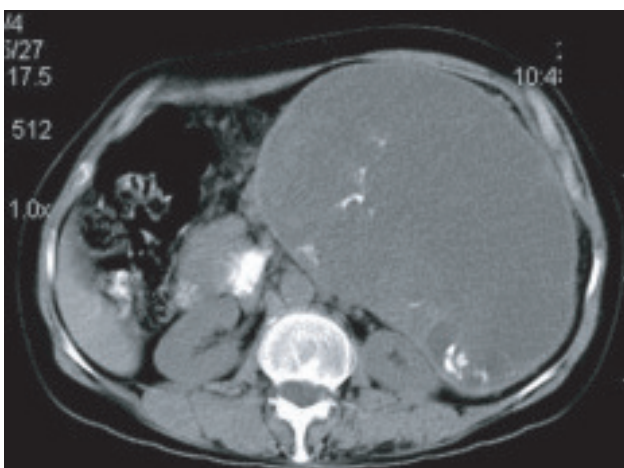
Plain CT scan –large cystic mass with central and peripheral calcification
